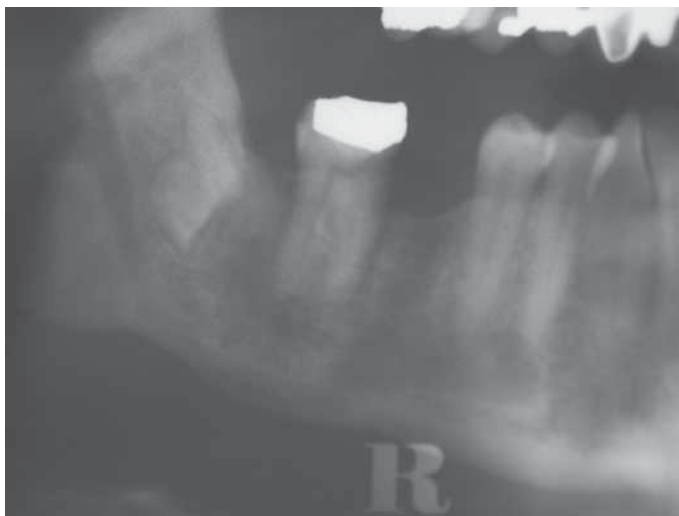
Post-operative review radiograph at 13 months demonstrating good bony healing and migration of retained roots antero-superiorly away from the inferior dental canal.
